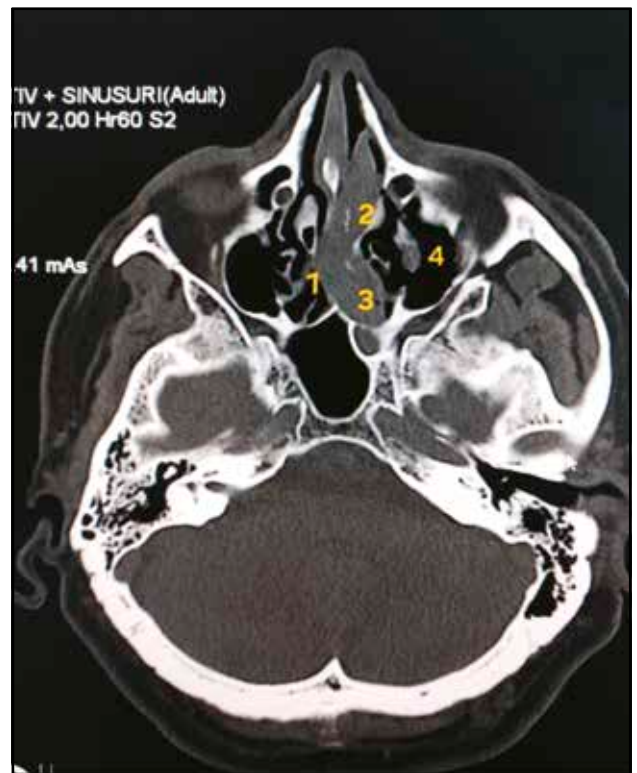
Crano-facial CT scan, coronal and axial sections, performed in 2025, showing: 1 – erosion of the nasal septum; 2 – tumor mass at the level of the left middle turbinate and middle meatus; 3 – posterior ethmoid cells occupied by the tumor mass; 4 – left maxillary sinus without pathological changes.
